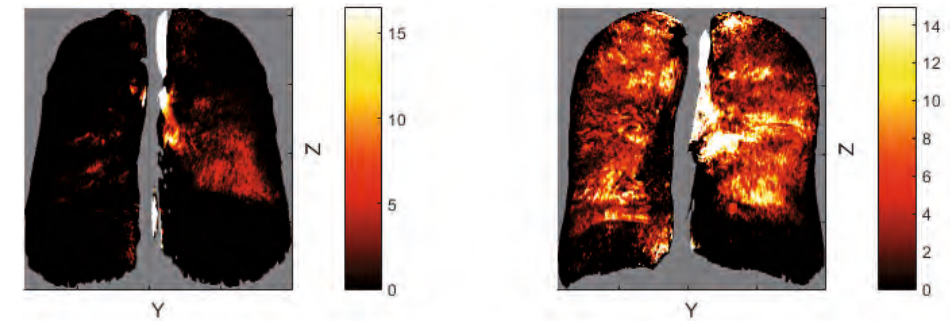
examples of parametric response mapping functional small airways disease (PRM^{fsad}) quantified by inspiration-expiration HR-CT. Left pair of lungs are from a subject with complete asthma remission, right pair from an asthmatic. Degree of color intensity resembles percentage of PRM^{fsad}.
